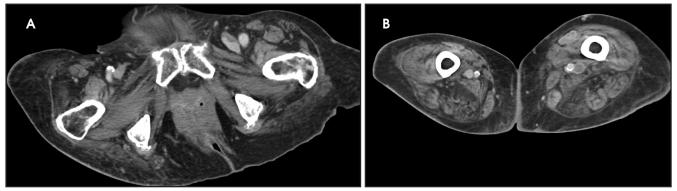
A 78-year-old woman with suspected pulmonary embolism. CT pulmonary angiography (not shown) revealed pulmonary edema and pleural effusions, but no evidence for pulmonary embolism. The CT venography portion of the examination (A,B) showed left inguinal and thigh deep venous thrombosis. (A) Transverse CTV image at the level of the symphysis pubis shows partial thrombosis of the left common femoral vein. (B) Transverse CTV image of the mid thighs shows expansile thrombosis of the left femoral vein, which is consistent with acute DVT. Note venous wall enhancement, and generalized edema and swelling of the left thigh.
